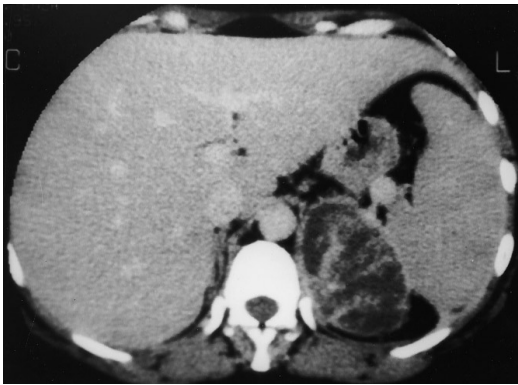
Second CT examination. The left adrenal mass has become much bigger and more hypodense. Thick septations may be seen after the administration of contrast material. The renal fascia is slightly thickened
